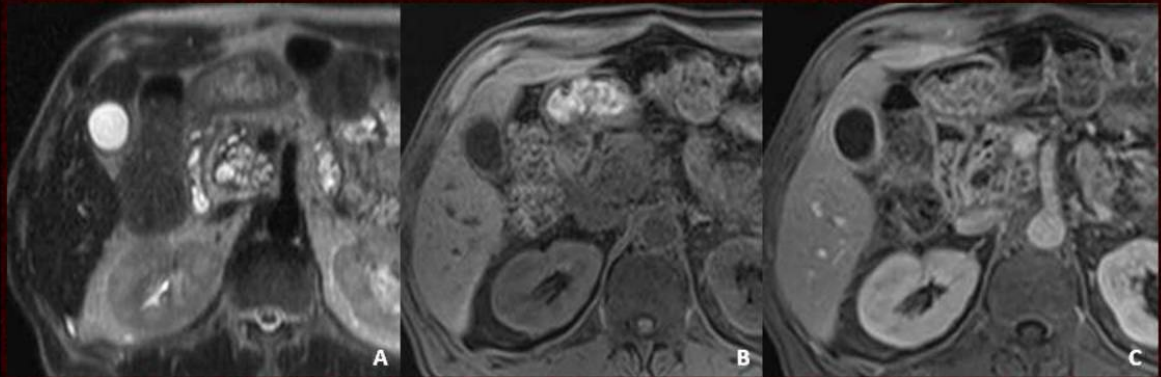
Side-branch type IPMT in a 66-year-old male, presenting with weight loss and anorexia. T2-weighted (A) and T1-weighted unenhanced (B) and contrast-enhanced (C) MR images show a cluster of small cysts (grape-like) in the uncinate process of the pancreas. (D-E) Projection MRPC discloses the communication of the lesion with the enlarged pancreatic duct. There is also bile duct ectasia.
